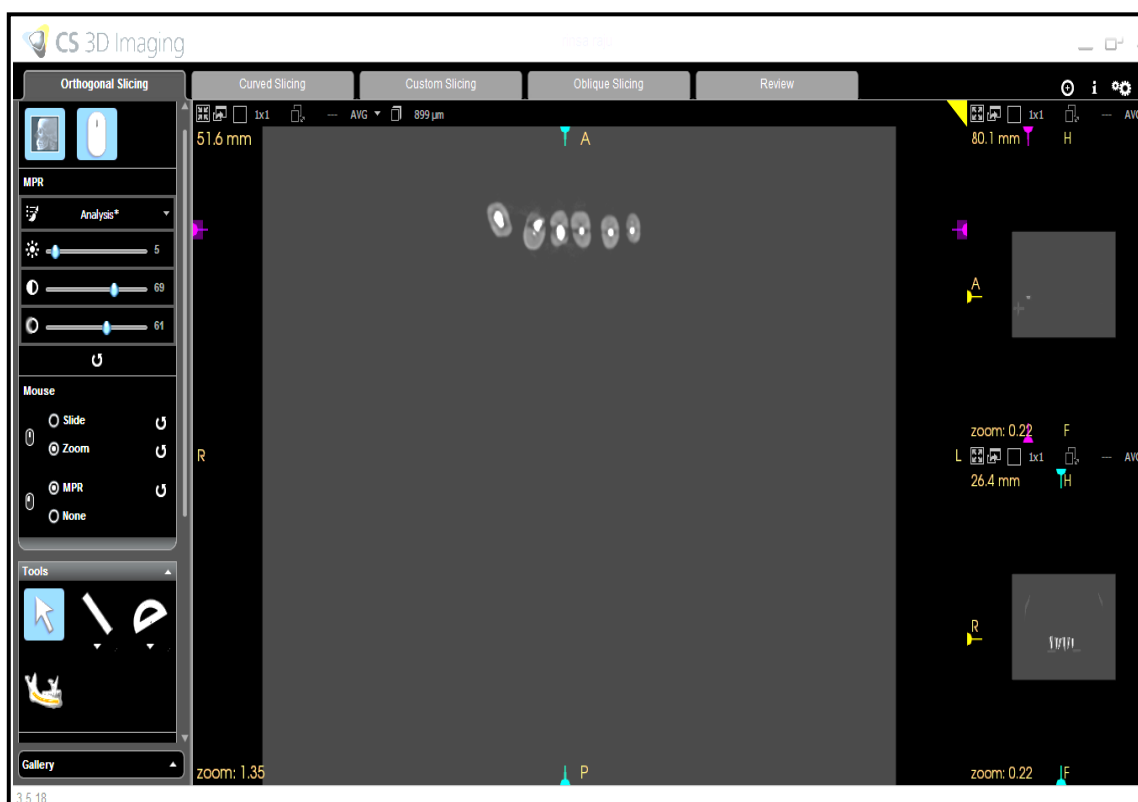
Sample placed on CBCT
